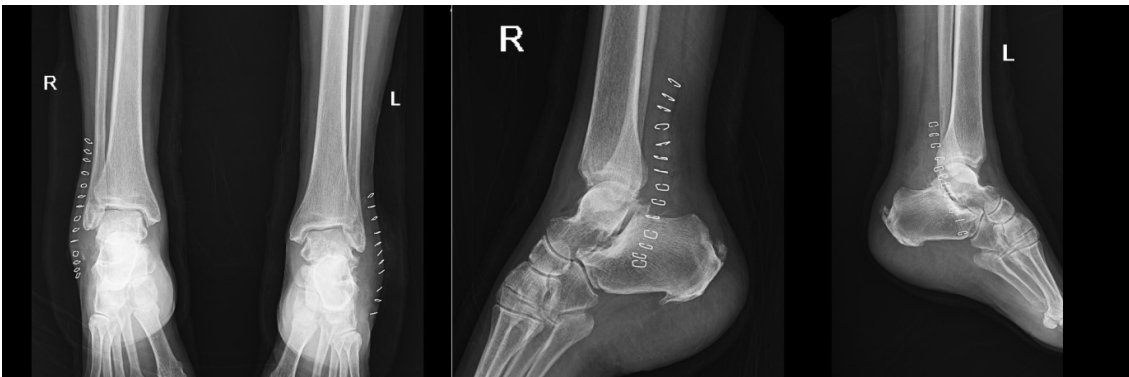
The plain radiograph anteroposterior and lateral view of the osteochondroma arising from talus bilaterally
